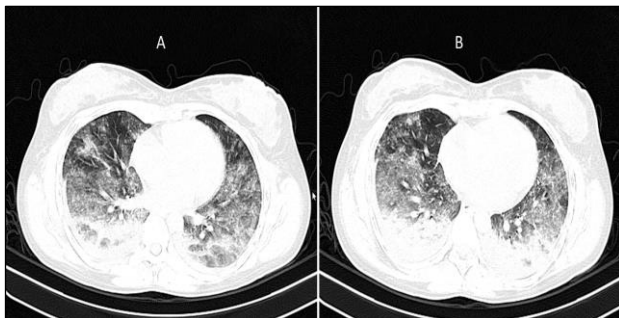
HRCT thorax showing non-segmental, subpleural opacity in the paravertebral gutter on both sides with less dense shadows towards the deeper parenchyma.
